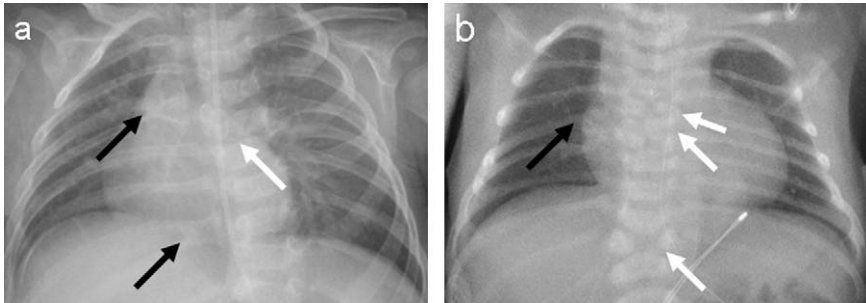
a Chest radiograph of patient 1 showing on the right side only 11 ribs and partial fusion of the dorsal part of both pairs of ribs 5/6 and 9/10 (black arrows), butterfly shape of the vertebral body T5, wedge-shaped of vertebral body T6 (white arrow), and nasogastric tube. b Chest radiograph of patient 2 showing on the right side fusion of ribs 4/5 (black arrows), butterfly shape of the vertebral body T4, T5, and T9 (white arrows), and nasogastric tube.
